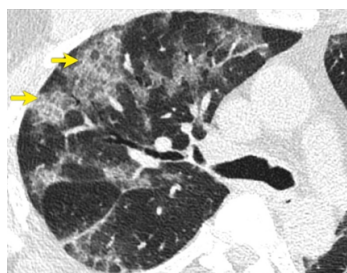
Axial CT image shows subpleural and peri-bronchovascular ground glass opacities with interstitial septal thickening(crazy paving appearance).
